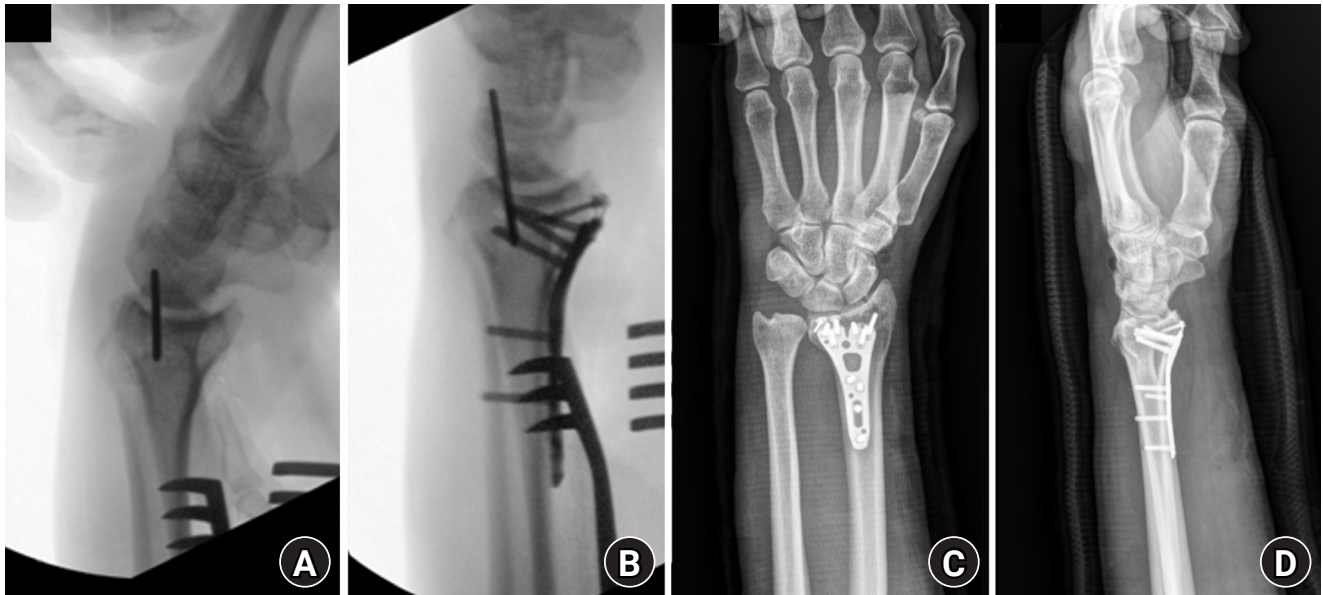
Intraoperative and immediate postoperative imaging. Intraoperative fluoroscopic images (A, B) demonstrated apparent restoration of radial height, inclination, and volar tilt following volar locking plate fixation. Immediate postoperative radiographs (C, D) demonstrated acceptable reduction without obvious dorsal translation or carpal malalignment.
